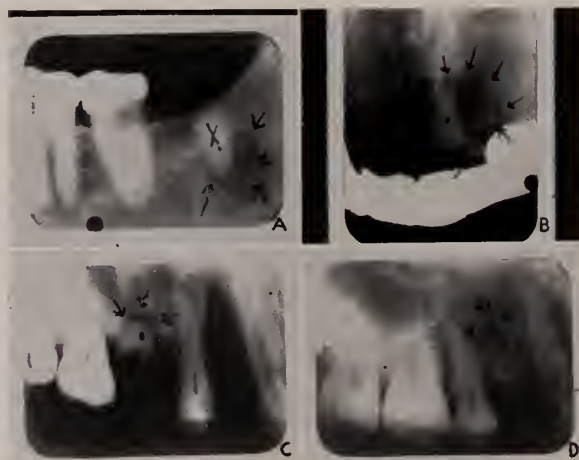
Roentgenograms showing residual areas of infection about roots left in after the ordinary method of extraction of teeth.
